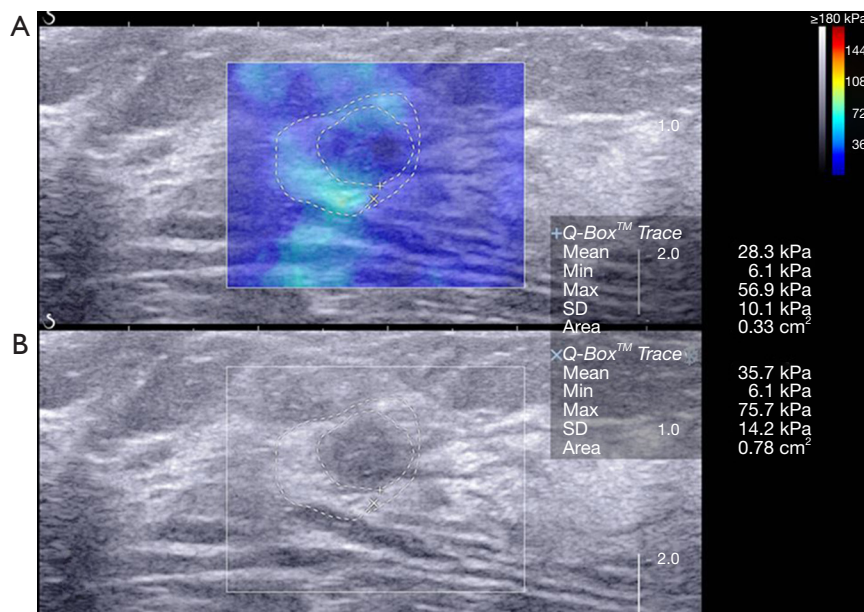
A 38-year-old woman diagnosed with grade II invasive ductal carcinoma. The US image (B) shows a 10 mm lesion assessed as BI-RADS category 4a, the SWE image (A) shows an Emax of 75.7 kPa. The lesion would be categorized BI-RADS category 4a by using the conservative approach with combined assessment of US and SWE, but it would be downgraded to BI-RADS category 3 by using the aggressive approach, resulting in a false-negative finding. SD, standard deviation; US, ultrasound; BI-RADS, Breast Imaging-Reporting and Data System; SWE, shear-wave elastography; Emax, maximum elasticity.
